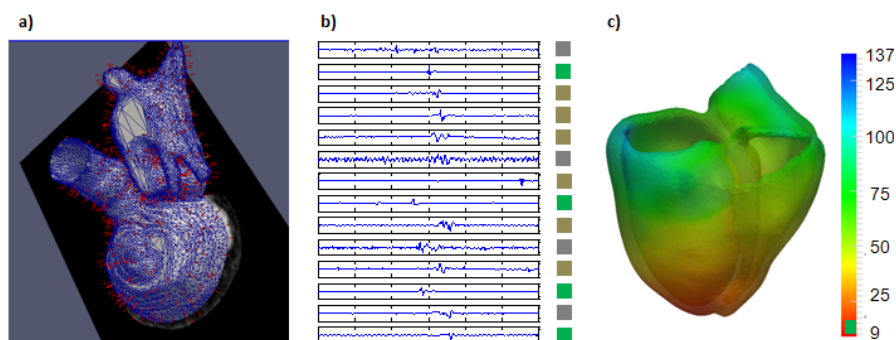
a) MRI Feature Extraction b) EP Signal Feature Extraction c) EP Model Personalization
